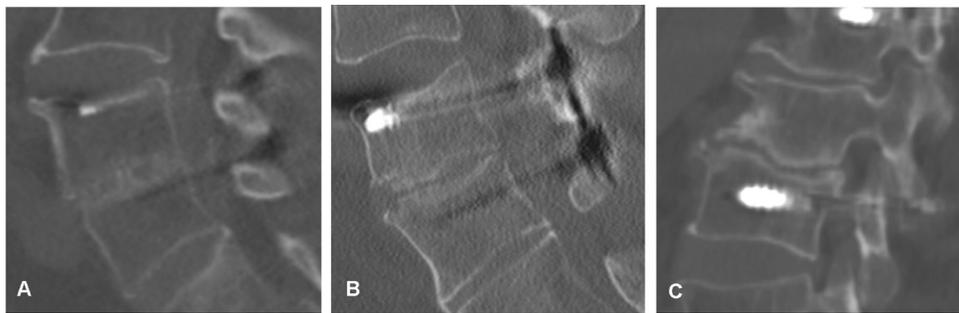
Postoperative CT at 1-year follow-up showing complete inter-body fusion (A), partial fusion (B), or nonunion (C).
